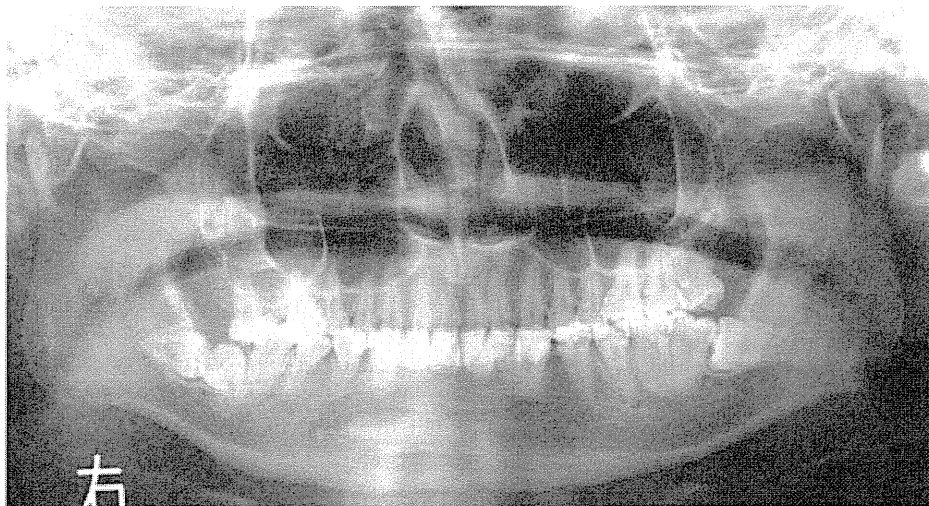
Panoramic radiograph at age 19 years and 5 months. Molars showed abnormal eruption or impaction. Seven molars were later extracted under local or general anesthesia.
